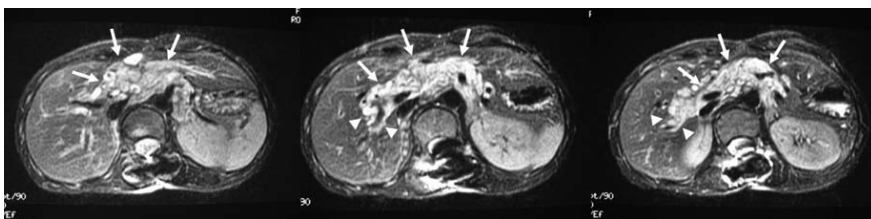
Abdominal MRI (T2-weighted image) showing a hyperintense tumor involving the hepatoduodenal ligament and the hepatic hilum (arrows), extending along the intrahepatic Glisson's sheath (arrow heads).
